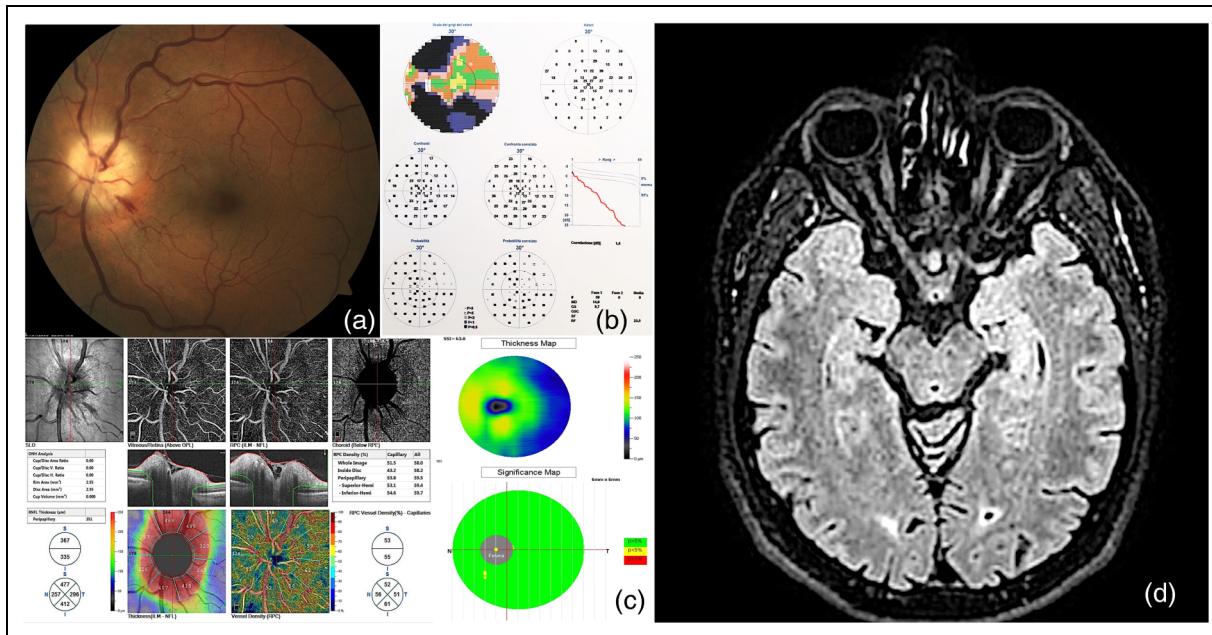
(a) Fundus color photograph of left eye shows optic disc swelling with peripapillary flame hemorrhages. (b) Visual field reveals diffuse peripheral depression and relative central sparing in left eye. (c) Optical coherence tomography angiography images demonstrate optic disc edema with Ganglion Cell Complex and Retinal Nerve Fiber Layer thickening and hyperdensity of perioptic radial peripapillary complex with increased flow density and a poorly defined deep capillary complex. (d) Brain nuclear magnetic resonance imaging shows diffuse left optic nerve hyperintensity in T2/flair without gadolinium enhancement.
